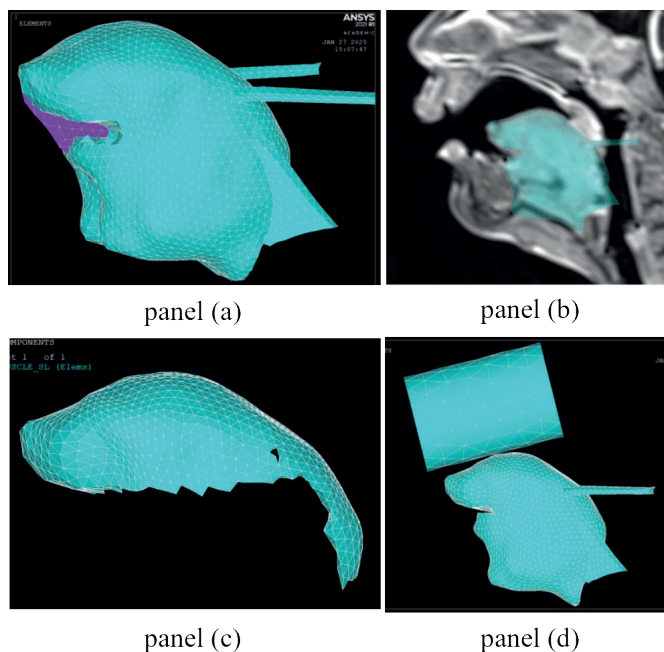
FE newborn model. Panel (a): FE newborn with anterior tongue frenulum (in violet). Panel (b): FE model superimposed on newborn MRI in the sagittal plane of the head. Panel (c): SL muscle. Panel (d): FE model with nipple model.
